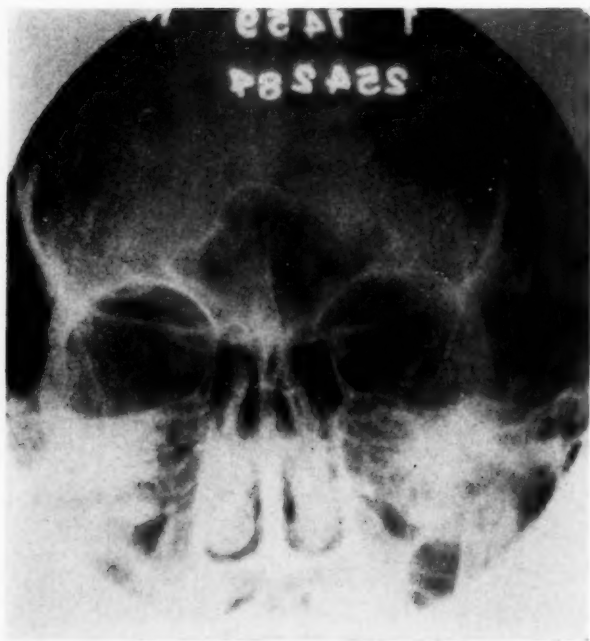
Case 2. Postoperative x-ray. Note the osteoplastic bone flap outline. The site of origin of the osteoma cannot be seen.
